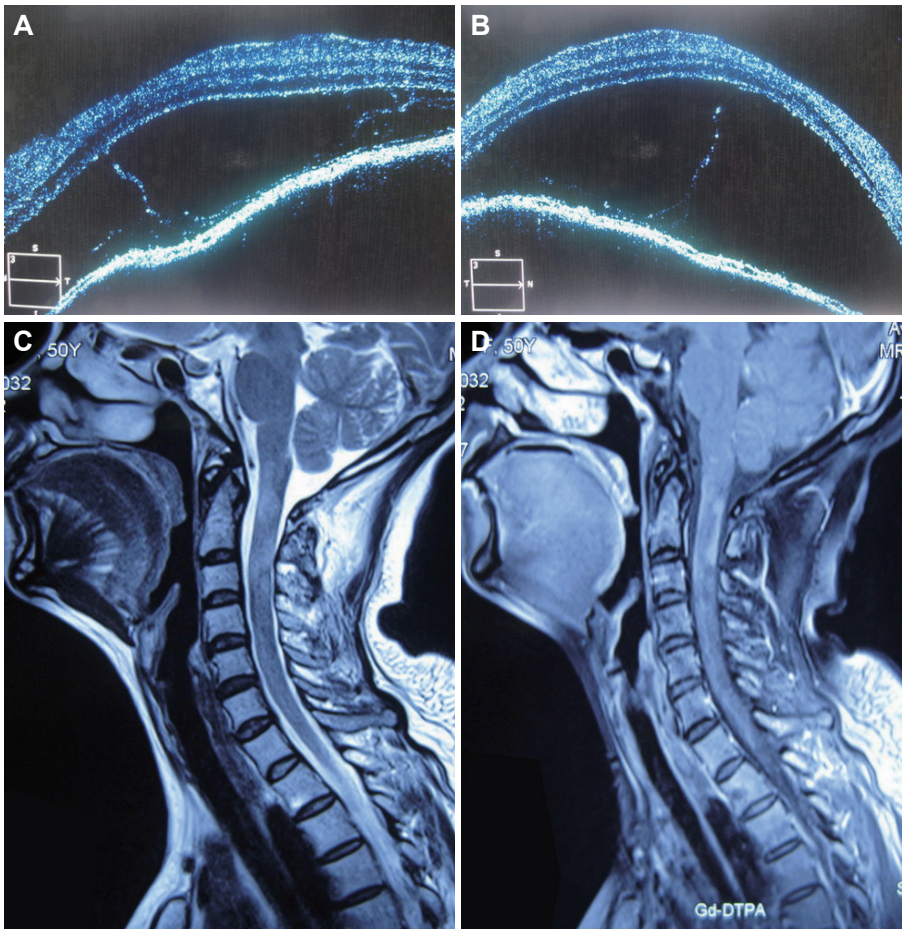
Optical coherence tomography demonstrating serous detachment of both eyes (A and B). T2-weighted sagittal view of the spinal cord showing a hyperintense signal of the cord at the level of the C1-3 vertebrae (C), and contrast-enhanced sagittal view showing gadolinium enhancement at the same level (D).
